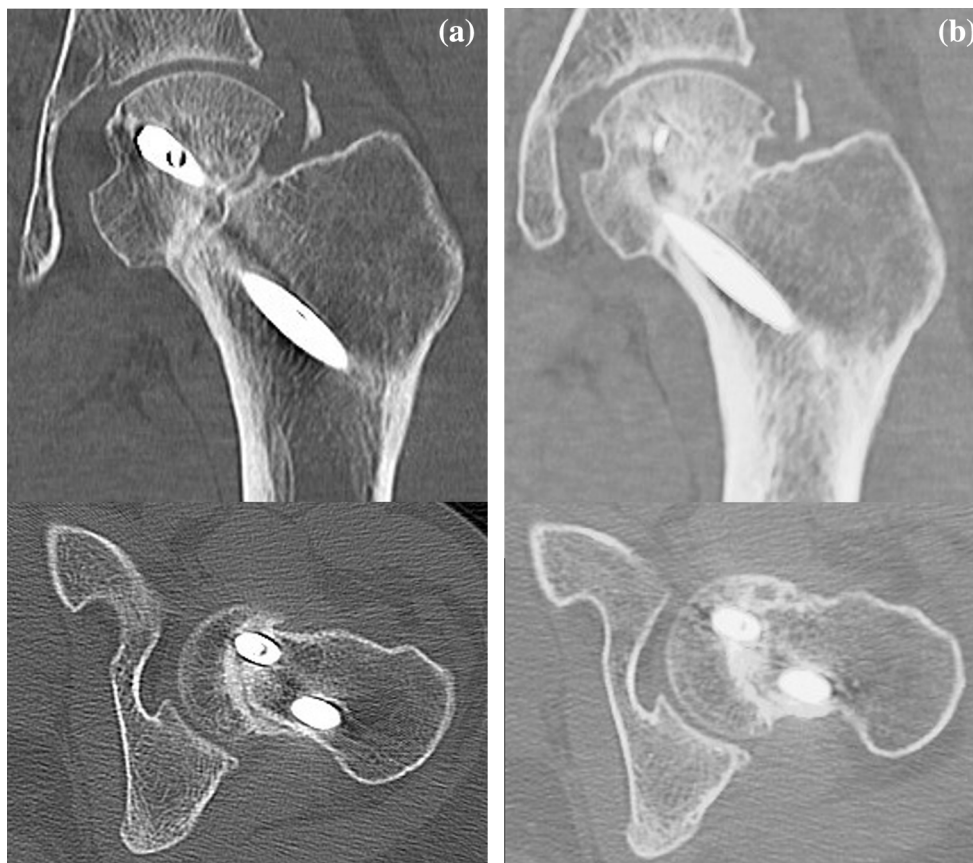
(A) A CT scan taken 11 months post-surgery showing that trabecular bridging only at the medial and anterior sites, thereby suggesting the presence of non-union of the femoral neck. (B) A CT scan taken 13 months post-surgery (8 weeks after the initiation of LIPUS treatment) showing bony union of the fracture.
